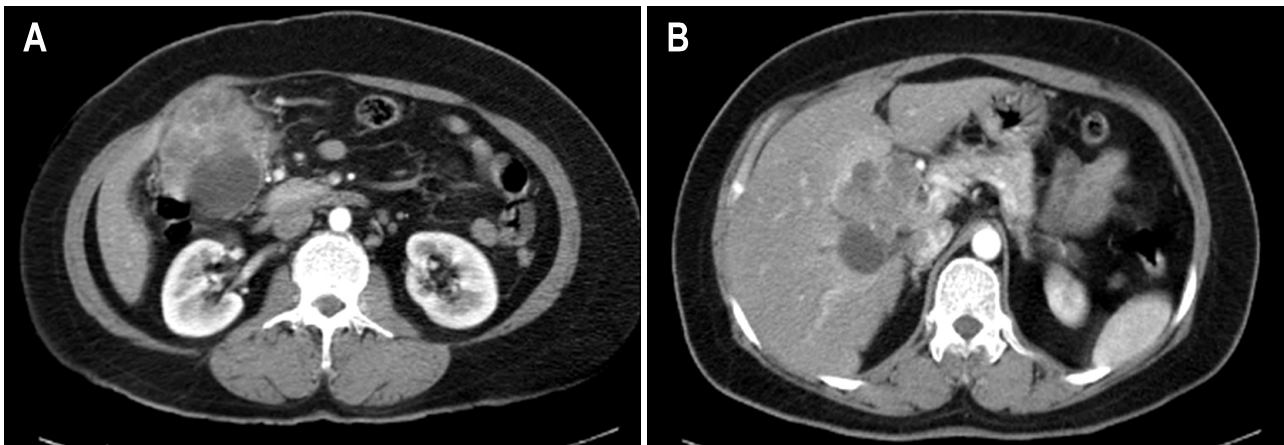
(A) CT scan showing a 7.8×6.2-cm exophytic necrotizing mass in the fundus of the gallbladder. (B) CT scan showing multiple conglomerated necrotizing lymphadenopathies in the hepatic hilum. The proximal CBD, cystic duct, portal vein, and hepatic artery were invaded.
